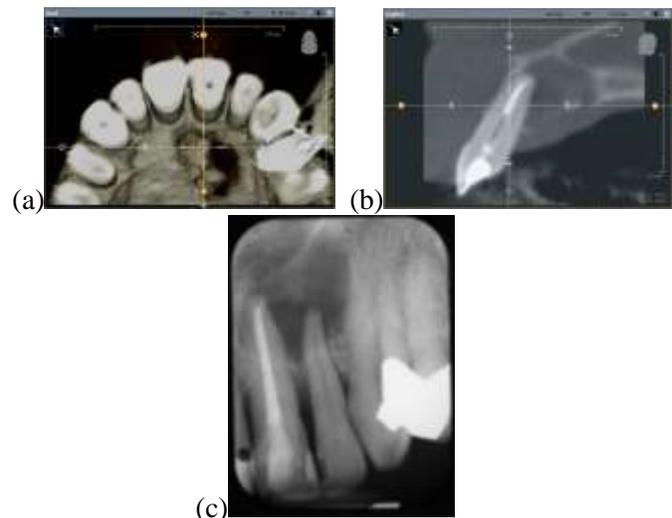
(a) CBCT Axial view, (b) CBCT Sagittal views and (c) Conventional periapical radiograph of tooth #9 & #10
